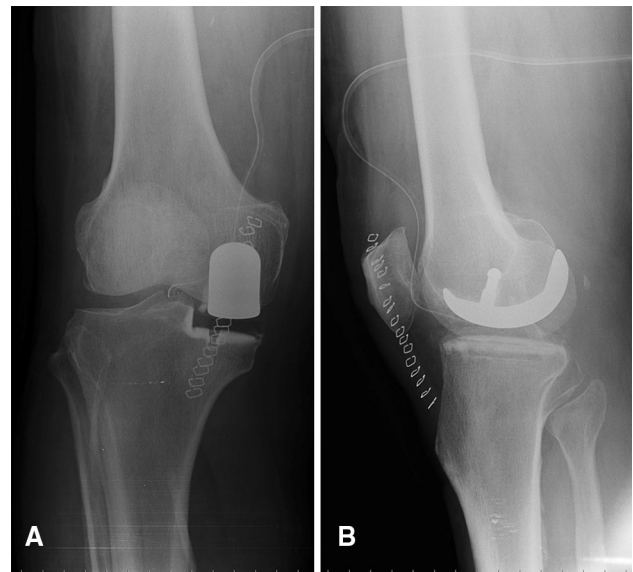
Post-operative radiograph: a frontal view, b lateral view
